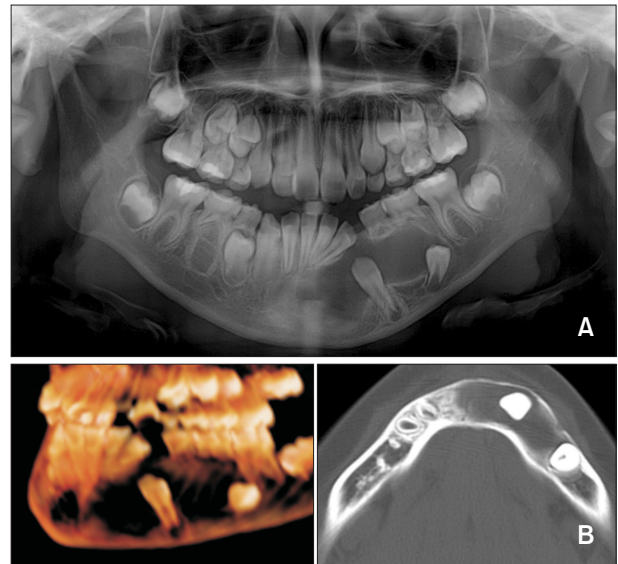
A, Panoramic radiograph acquired before marsupialization of the cyst. B, Pretreatment computed tomographic images acquired before marsupialization of the cyst.
